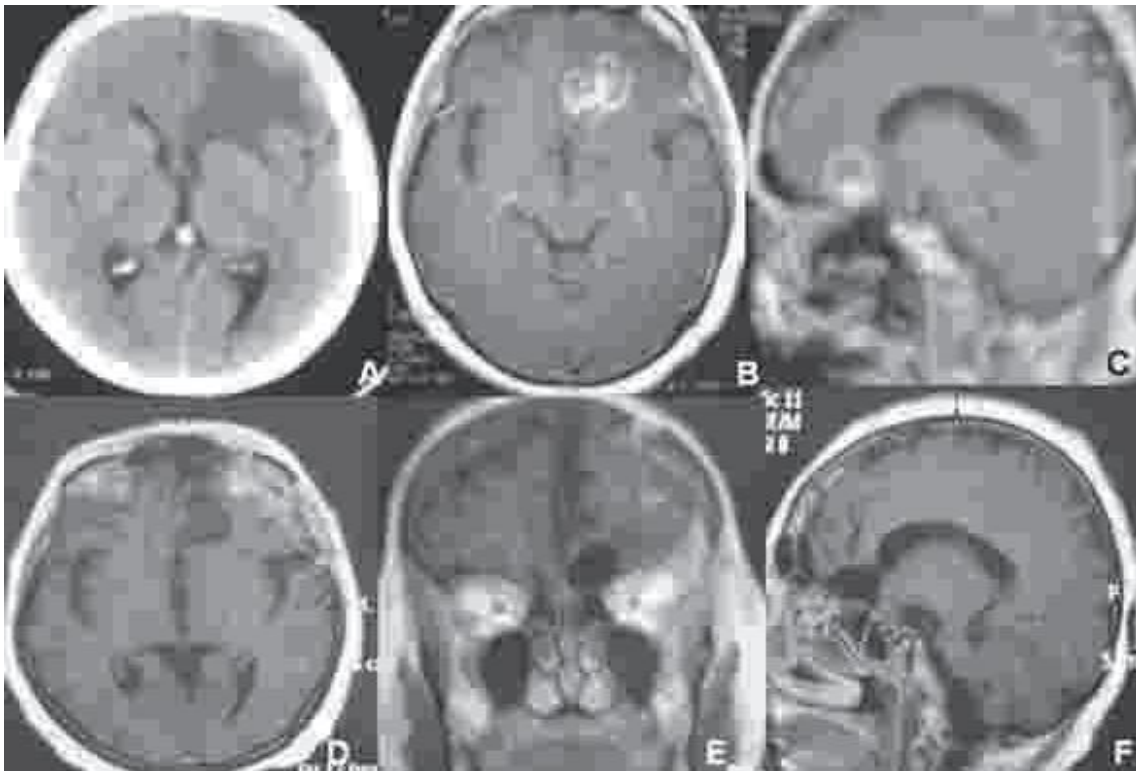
Pre (A,B and C) and postoperative (D,E and F) studies. A. Axial non Contrast-enhanced CT showing large left frontal brain edema. Contrastenhanced axial (B) and sagittal (C) MRI showing abnormal ring enhancement around the lesion after radiosurgical treatment. Postoperative contrast-enhanced axial (D), coronal (E) and sagittal (F) MRI showing total lesion resection.
